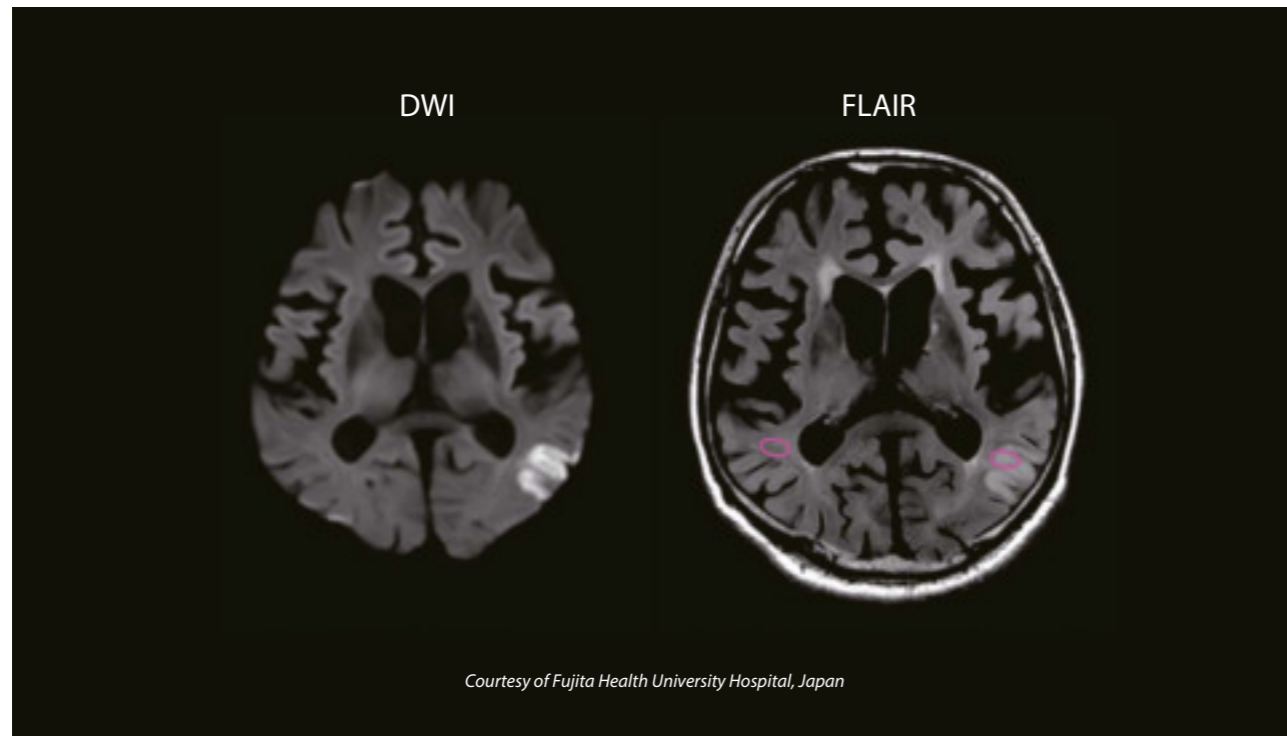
Examples of DWI-FLAIR intensities. (A) DWI-FLAIR mismatch (DWI+/FLAIR-): hyperintensity is present on DWI but not on FLAIR. (B) No DWI-FLAIR mismatch (DWI+/FLAIR+): hyperintensity is present on both DWI and FLAIR. DWI: diffusion-weighted imaging, FLAIR: fluid-attenuated inversion recovery. Adapted from²⁸.
